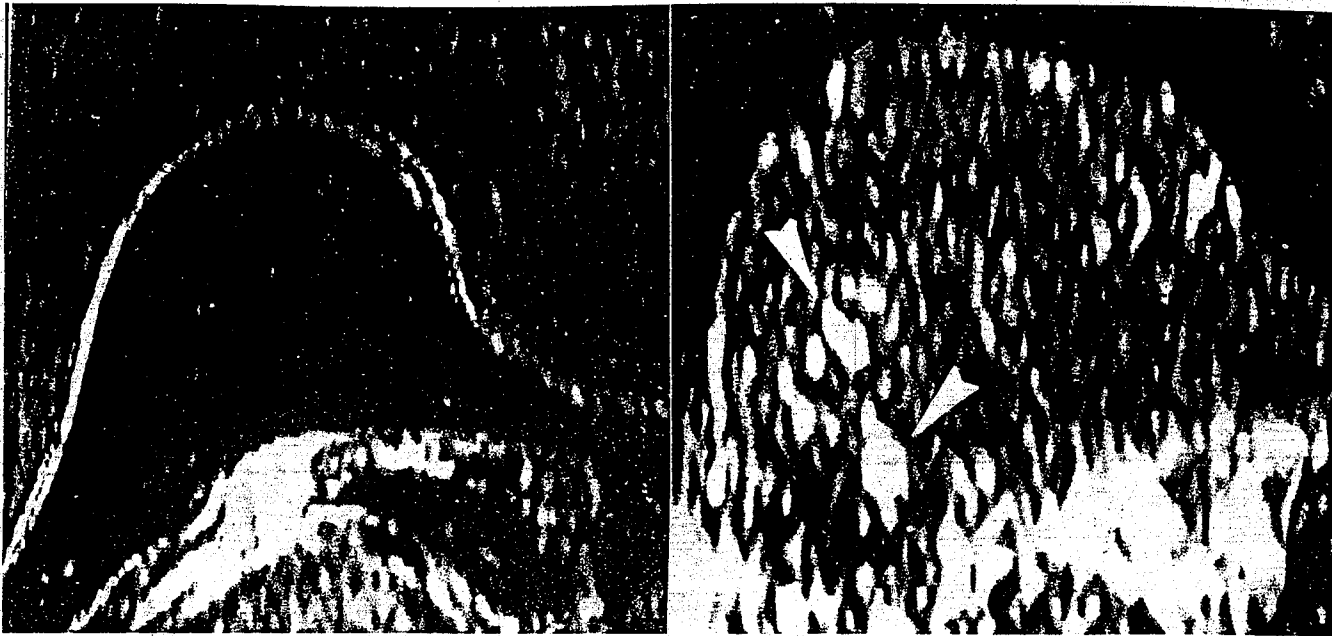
A) Breast MR image of the 2000 year: the exam is negative for breast cancer. B) Breast MR image of the 2001 year: multiplanar reconstruction, after subtraction, of the axial plane. The two tumor foci are clearly depicted (arrows).
